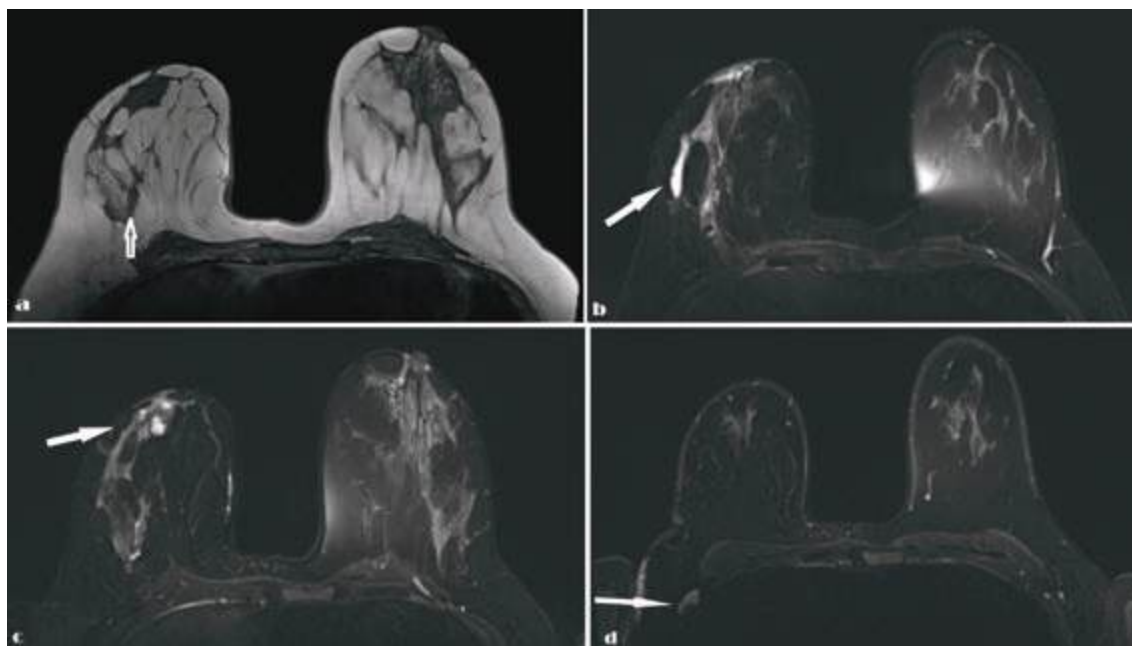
Breast MRI findings in multicentric right breast abscess.
